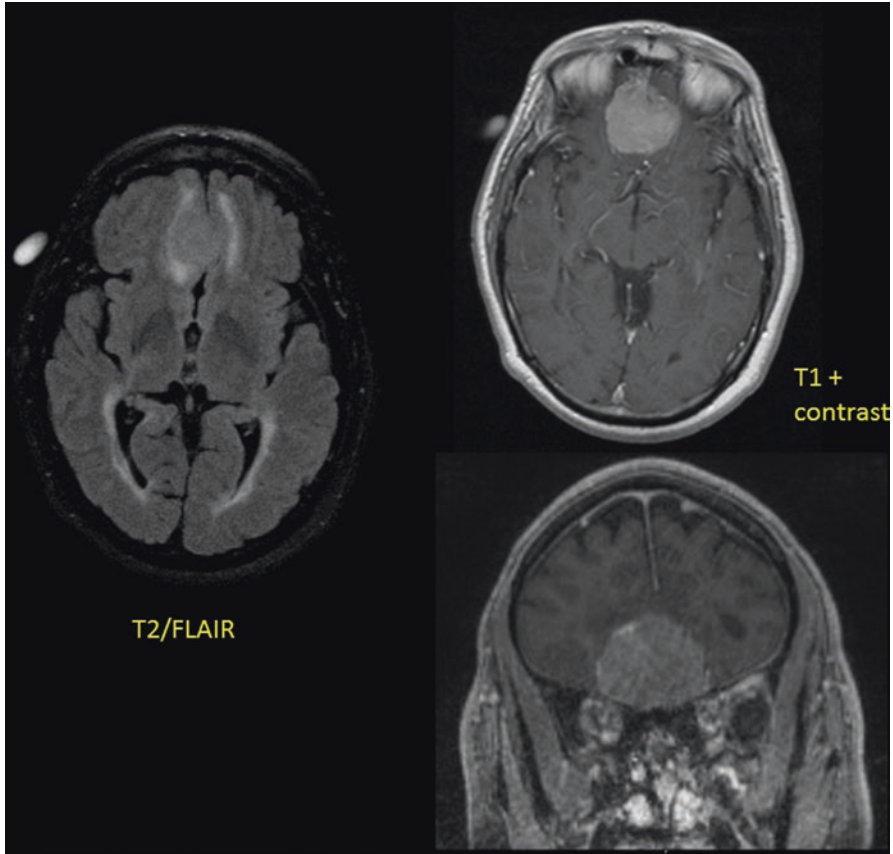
Brain MRI prior to surgery for Mr. C (Case 3). Orbitofrontal meningioma has minimal surrounding edema. FLAIR imaging shows periventricular hyperintensity due to demyelination from multiple sclerosis
